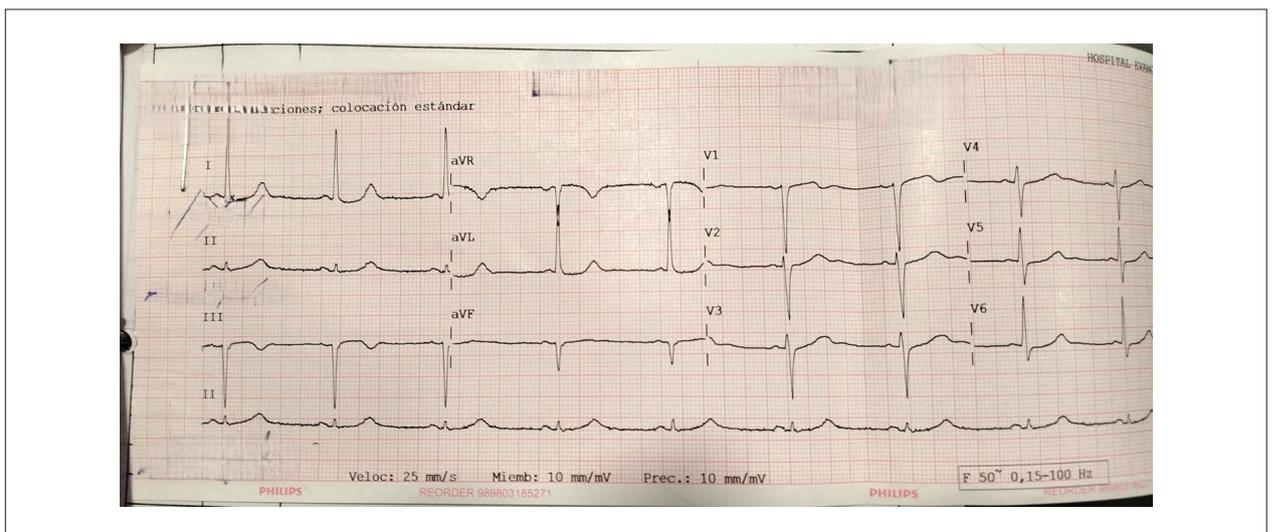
Echocardiogram showing positive T waves with a corrected QT interval of 480 ms.
